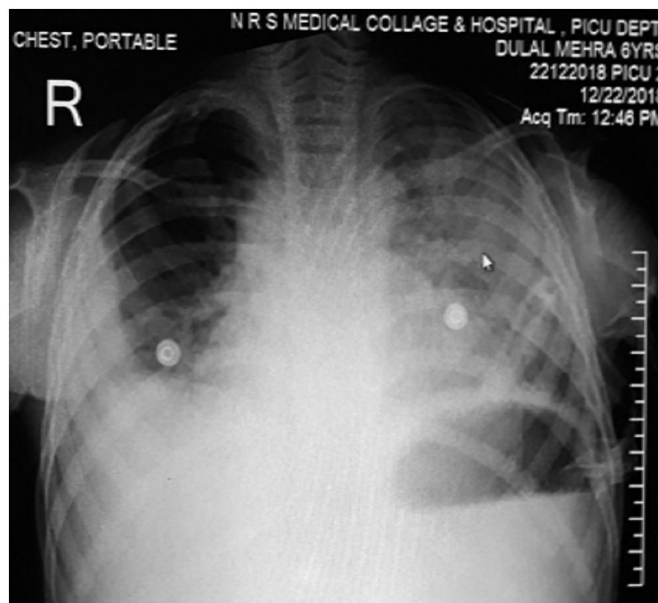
Chest X-ray of Case 1 showing bilateral pleural effusion and left sided ICD in situ
